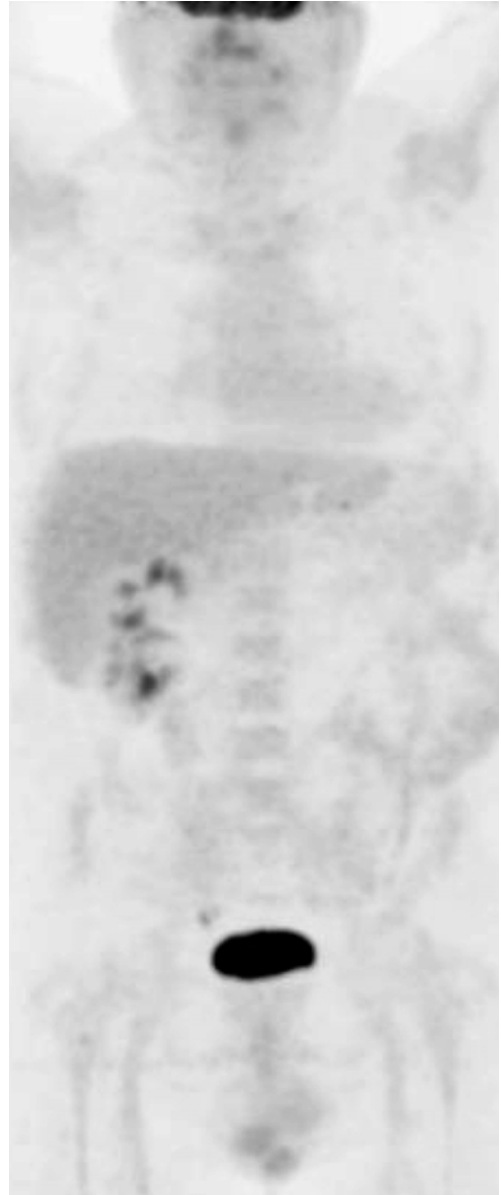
Normal end-of-treatment PET/CT
